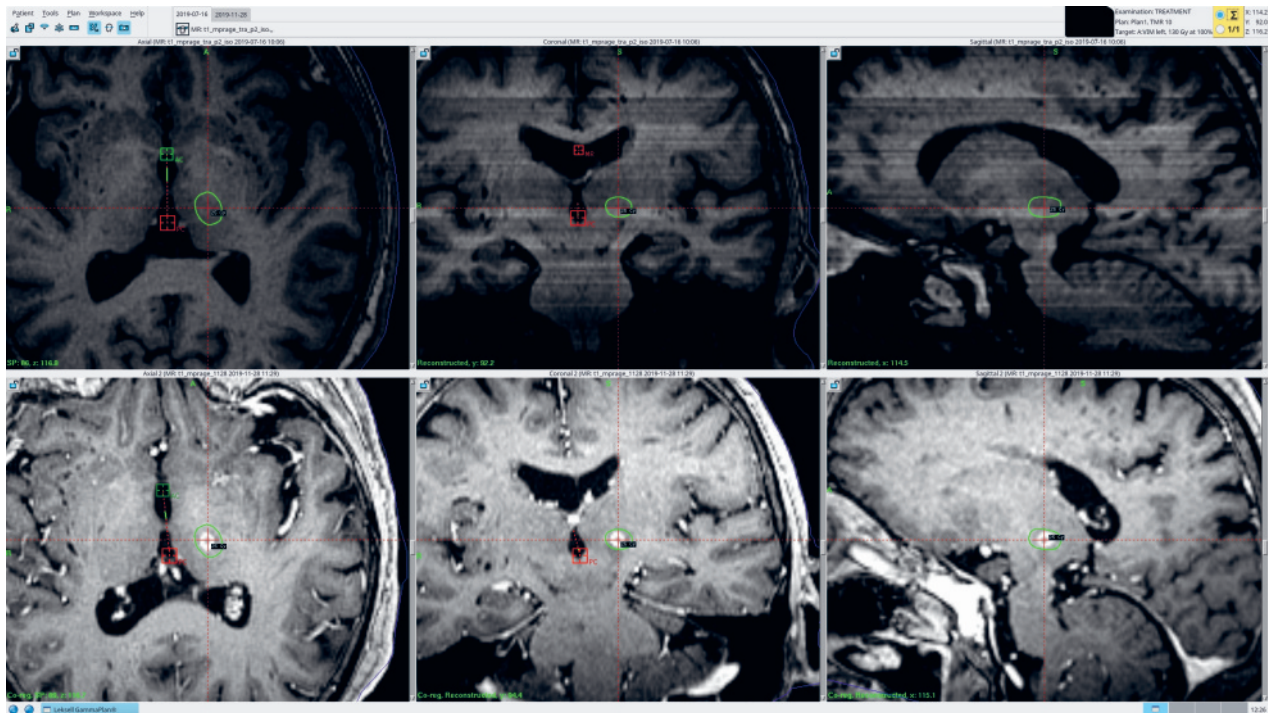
Brain MRI before and after gamma knife thalamotomy.
